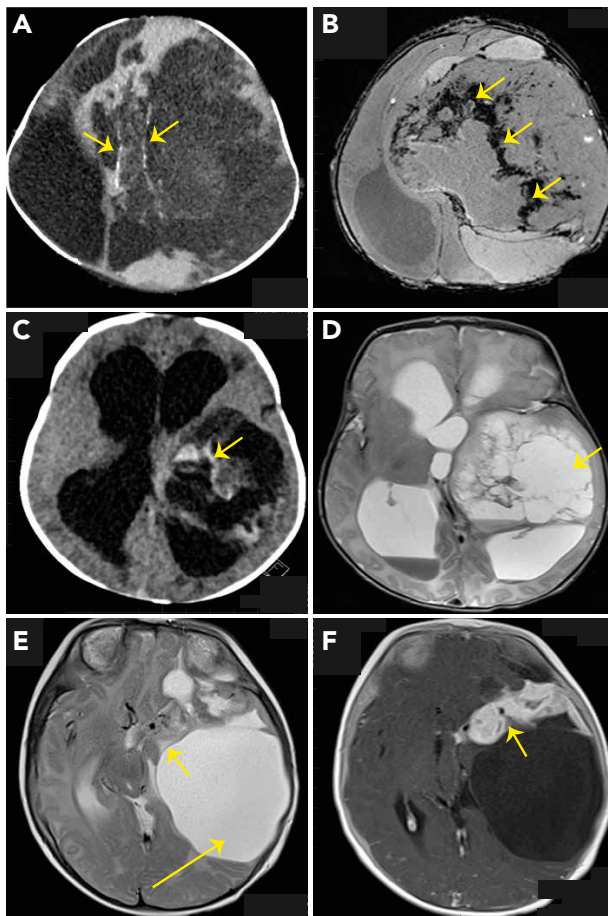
(A) Axial head CT of a 42-day-old male with enlarging head circumference showing a left hemispheric mass with linear calcification (arrow). (B) Axial GRE sequence of the same patient demonstrating extensive susceptibility artifact (arrows) representing microhemorrhage. (C) Axial head CT of a 21-day-old female with enlarging head circumference showing a left hemispheric mass with a hemorrhagic solid component (arrow). (D) Axial T2 image showing cystic components (arrow) in the same patient. (E) Axial T2 image of a 5-month-old male with an atypical left hemispheric IHG showing a medial, nonhemorrhagic solid component (short arrow) and peripheral cystic components (long arrow). (F) Axial postcontrast T1 MPRAGE sequence of the same patient demonstrating avid enhancement of the solid component (arrow). Images are from unpublished cases treated within St. Jude Children's Research Hospital. Appropriate Institutional Review Board permission was obtained prior to use and submission of the data (IRB#21-08005). Abbreviations: GRE, gradient-echo; IHG, infant-type hemispheric glioma; MPRAGE, magnetization-prepared rapid gradient echo.
